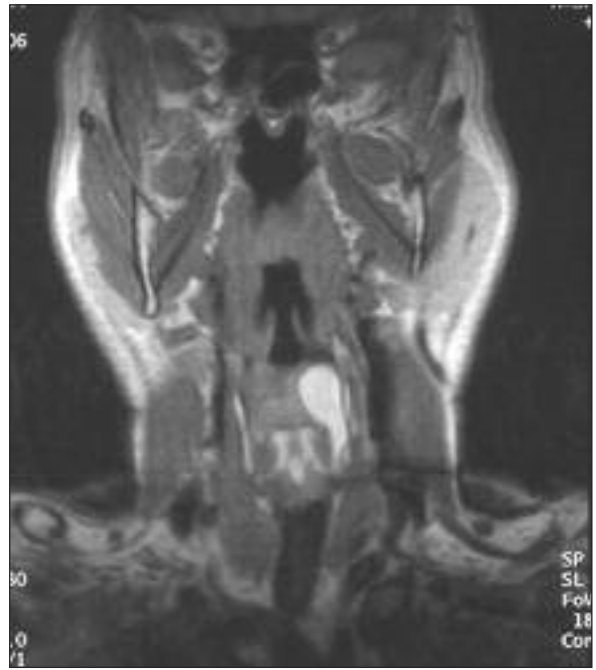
The subglottic extension of lipoma is demonstrated on coronal T1 weighted MR image.
